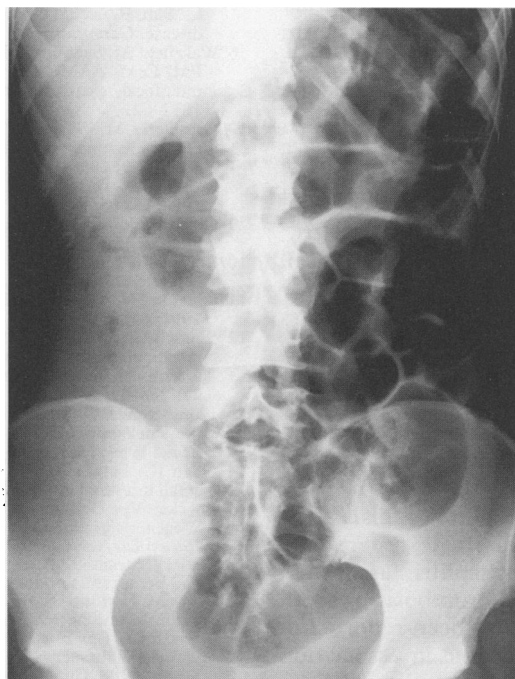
Plain abdominal radiograph showing dilated small intestine with an apparent mass containing a small amount of gas occupying most of the right side of the abdomen.
